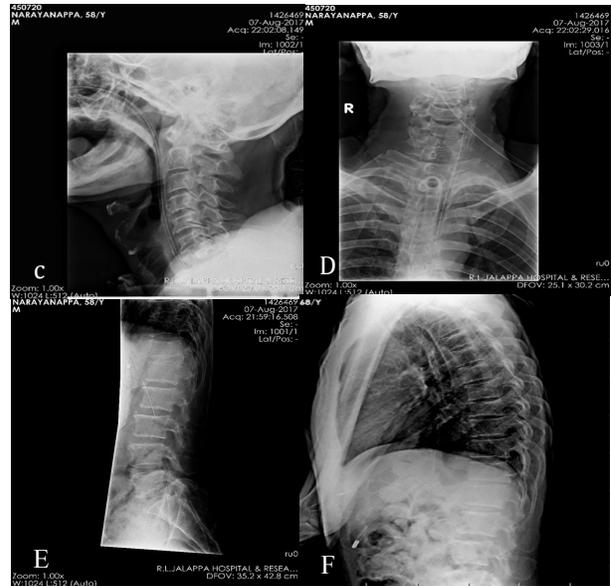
Figure C,D,E,F : X-rays of cervical, lumbar and thoracic spine to rule out tendon avulsions and crush fracture due to muscle spasms.
